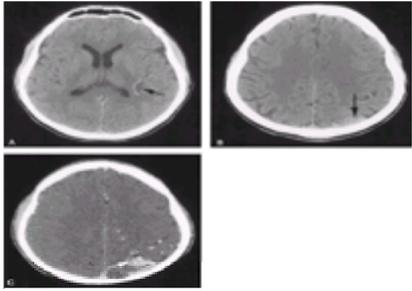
Arteriovenous malformation. A 39-year-old man with several days' headache. A: Noncontrast computed tomography shows enlarged, slightly hyperdense vessels in the sylvian fissure (*arrow*). B: Hyperdense, dilated veins at the varietal vertex (*arrow*). C: Computed tomographic angiography shows the arteriovenous malformation nidus as well as dilated feeding arteries and peripheral draining veins.
